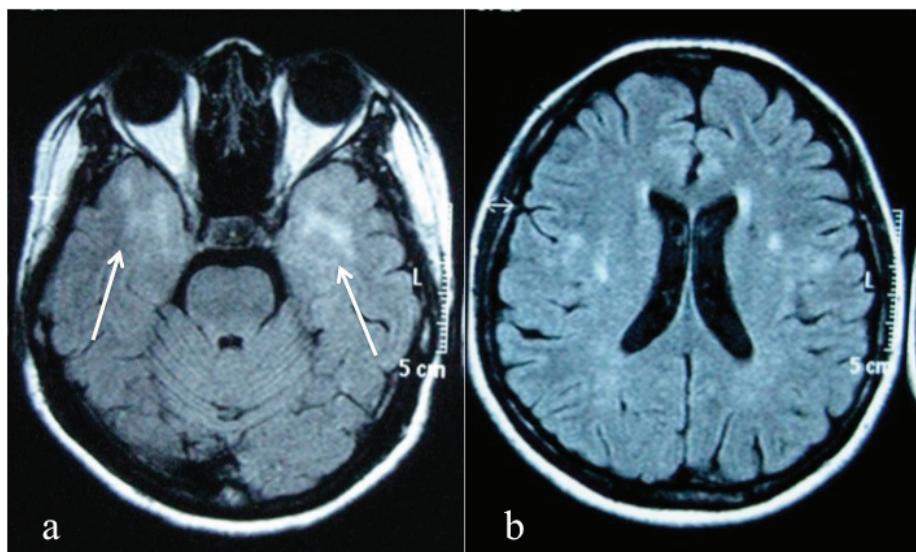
MRI axial FLAIR images (a , b) done in June 2011 following new symptoms of memory impairment and chorea from relapsed encephalitis. a) There were new confluent hyperintense lesions located at anterior temporal lobes bilaterally affecting the white matter and cortex (white arrows). b) The previously seen white matter lesions in the fronto-parietal lobes had remained unchanged in appearance.
